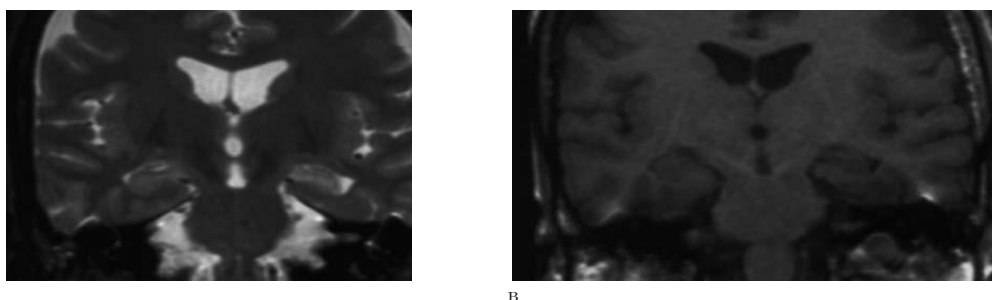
T1 and T2-weighted im-ages showing atrophy of the left hippocampus with high signal intensity on the T2 sequence.
